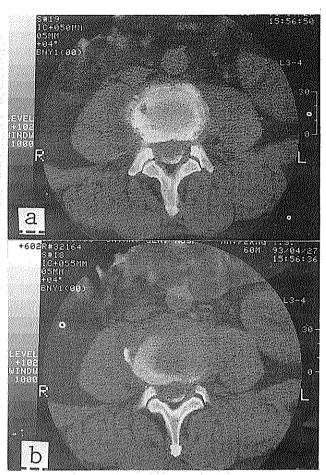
CT myelography revealing erosion of the vertebral end plates (a), in addition to anterior extrathecal sac lesion and obliteration of the fat plane around the vertebral body (a, b).
